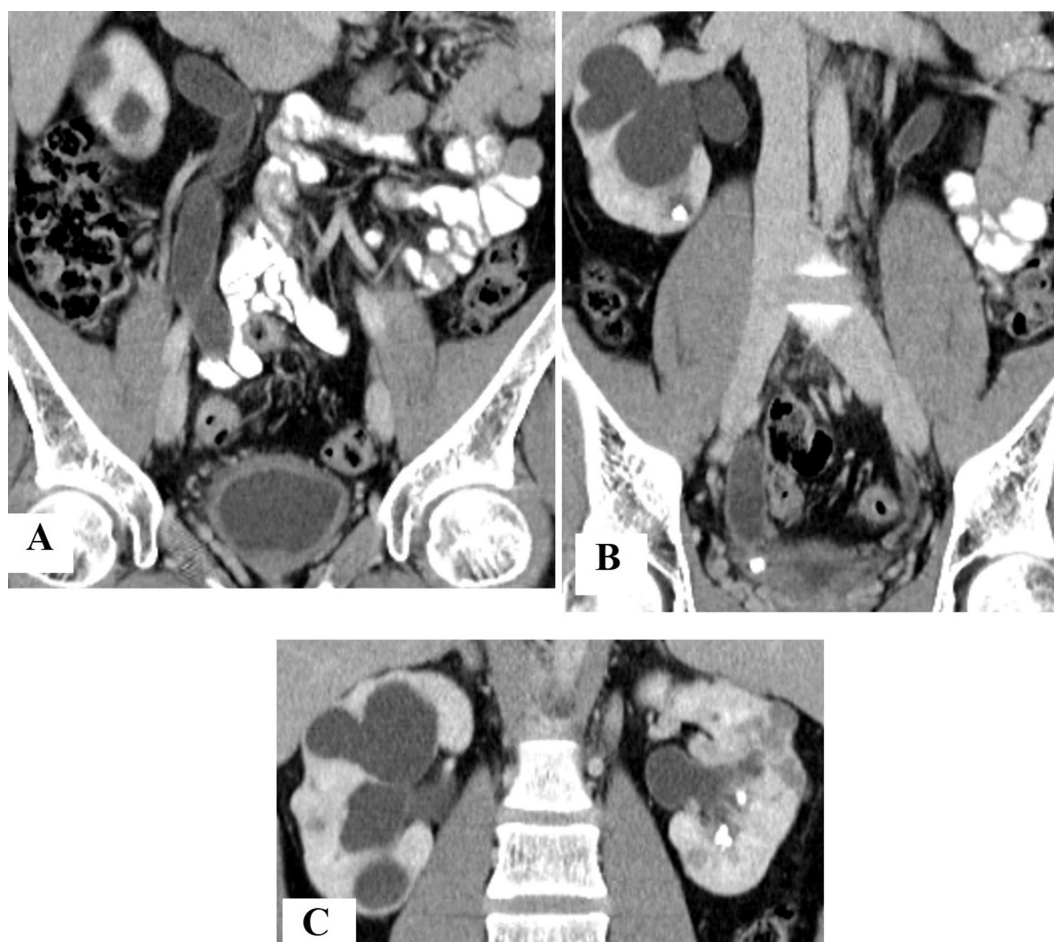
CT abdomen and pelvis: Rapid grower mycobacterium (speciation not done). (A) Dilated right calyces, ureter, shrunken and thick walled bladder. (B) Bilateral PCS dilatation, cysts, stones and calcification. (C) Right ureteropelvic and left lower calyceal stones, bilateral ureteral dilatation.
